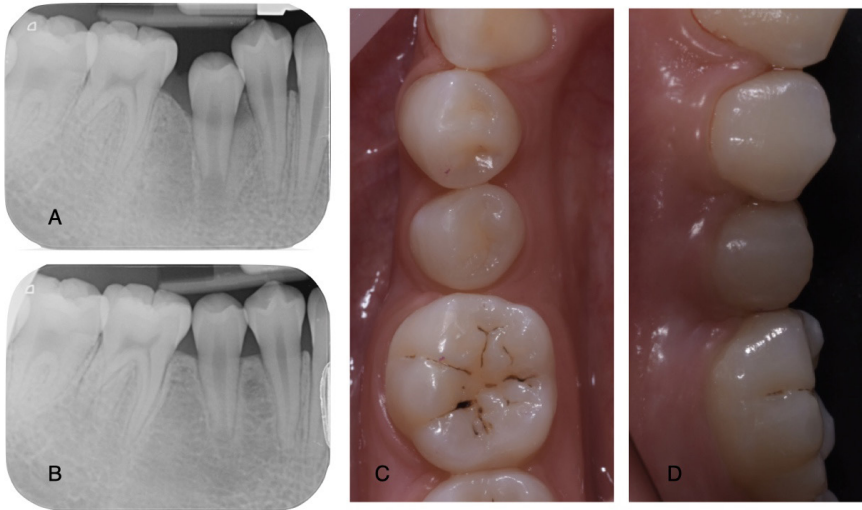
Follow-up periapical radiographs after 5 (A) and 7 years (B), showcasing the long-term outcomes of the apexification procedure, assessing the healing of the periapical lesion, and noting the development of the supernumerary premolar. Intraoral photographs confirming the clinical healing of the sinus tract (C, D).
